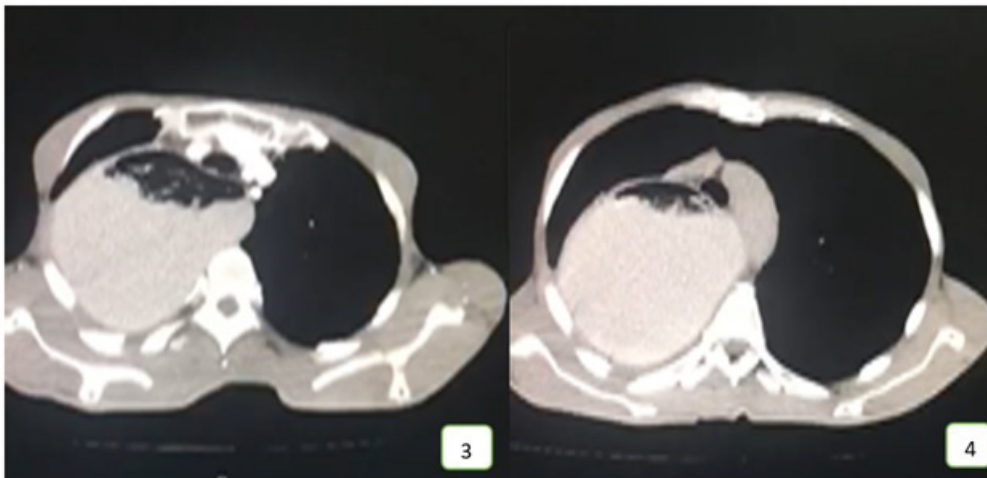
CT-scan of the chest show cystic and solid lesion with air fluid level and compress the trachea
